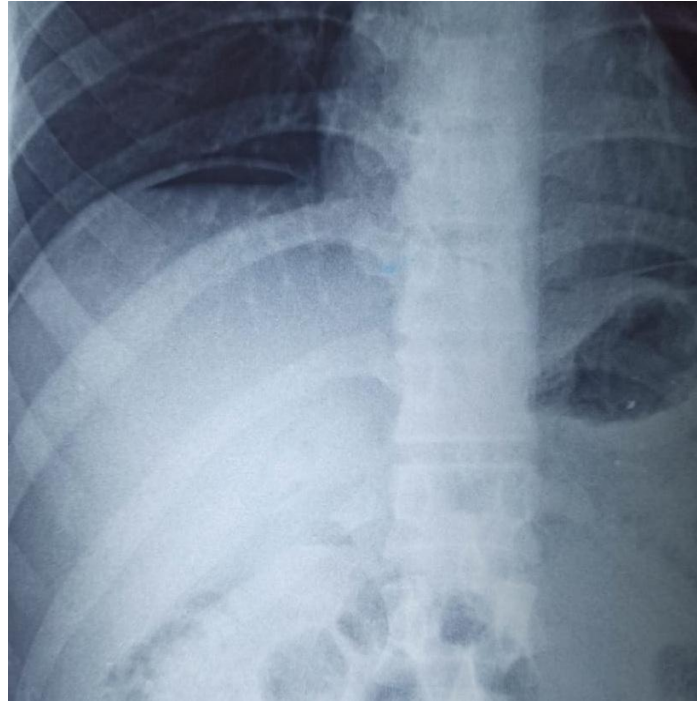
Free gas shadow under right dome of diaphragm in plain radiograph of abdomen
